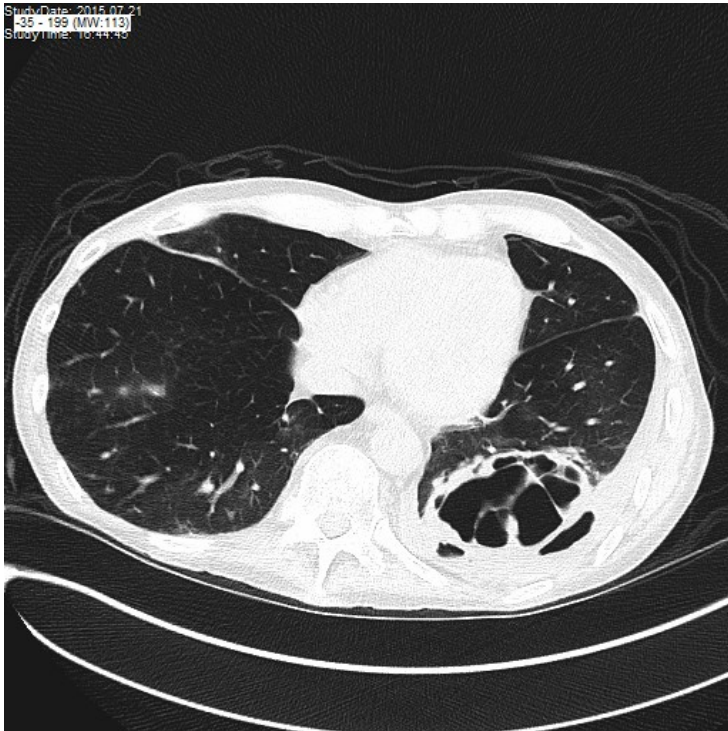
Two different slices of the chest CT scan of patient F.S. approximately one month after the initial CT scan above, showing a progression of the cavernous lesion
